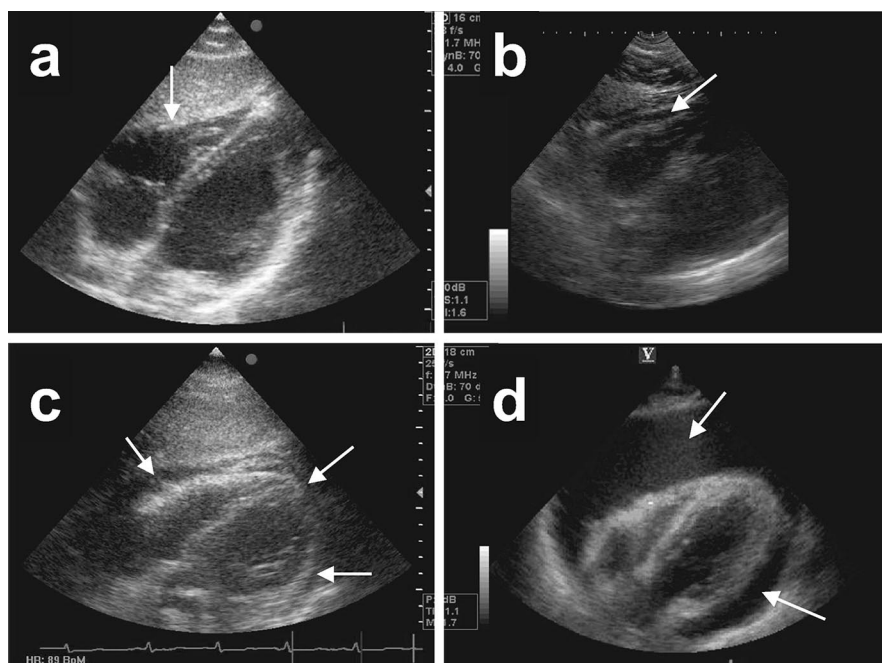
Differential diagnosis in emergency echocardiography of pericardial effusion. In the subcostal window, long axis, *arrows* indicate physiological pericardial fluid (*a*), anterior fat pad (*b*), small effusion (*c*), and massive effusion (*d*) with functional relevance.
